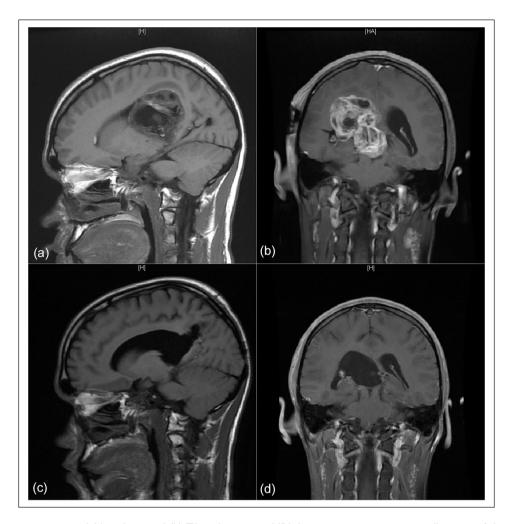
Preoperative sagittal (a) and coronal (b) T1 with contrast MRI demonstrating giant germ cell tumor of the pineal region. Postoperative sagittal (c) and coronal (d) T1 with contrast MRI following gross-total tumor resection.
